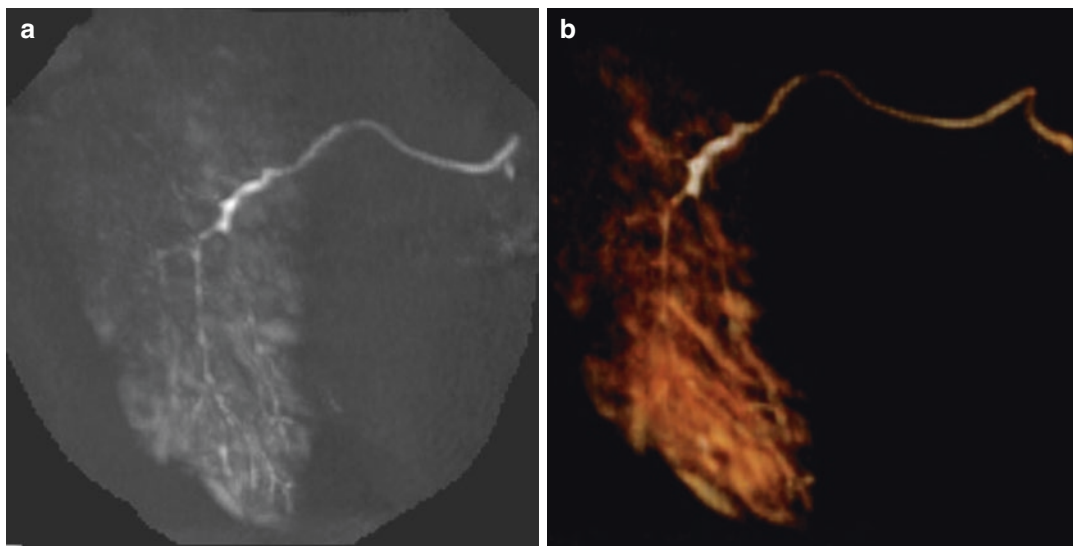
Reformatted sagittal MIP (a) and 3D volume rendering (b) of CBCT sialography image of the right parotid gland. The images demonstrate multiple globular
